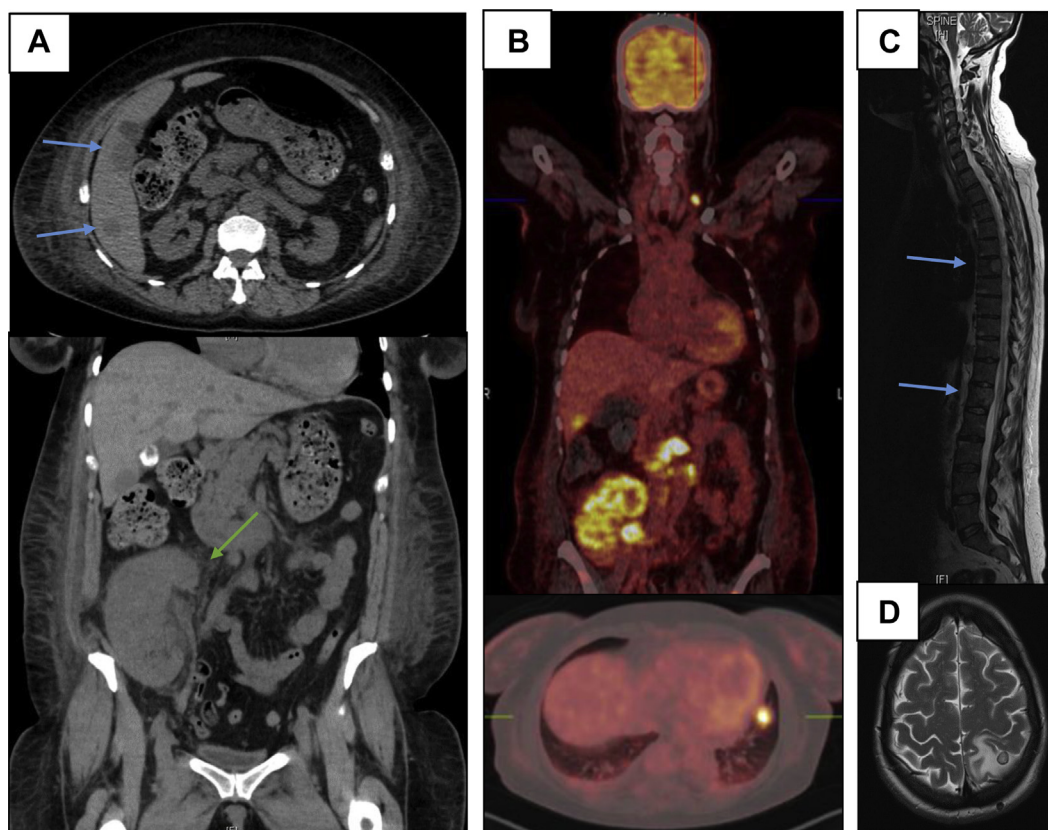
Medical imaging for case 3. (A) CT of the abdomen shows two lesions (blue arrows) in segments IV and V of the liver, enlargement of para-aortic lymph nodes, a slightly dilated ureter, and peri-renal fat infiltration of the kidney graft (green arrow). (B) 18F-FDG PET scan reveals increased tracer activity of the whole kidney graft and hilus with multiple hot spots in the liver, lung, and lymph nodes (retroperitoneal, left supraclavicular lymph node). (C) T2-weighted MRI of the spine shows bone metastases in the vertebral bodies of Th7, Th12, Th11, L1, L2, and L5. The most prominent lesions in Th7 and L1 are marked with blue arrows. (D) T2-weighted MRI of the brain shows a 9-mm nodular lesion in the left parietal subcortical region surrounded by vasogenic edema.
